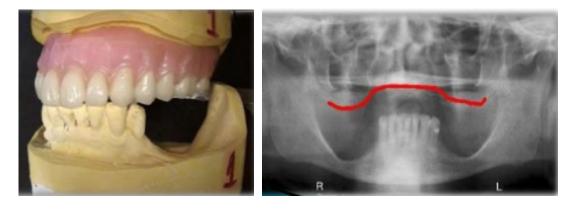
Combination syndrome patient's cast and x-ray.
